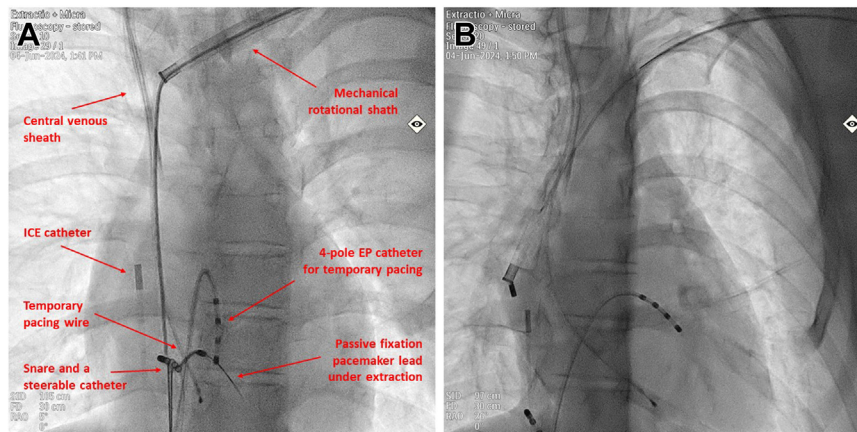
Transvenous extraction of a 10-year-old passive fixation right ventricular pacemaker lead. A: Due to massive adhesions on the lateral side of the superior vena cava, caudal traction was applied using a snare and a steerable catheter from the right femoral vein. B: Successful removal of the lead without radiologically visible residues. EP = electrophysiology; ICE = intracardiac echocardiography.
